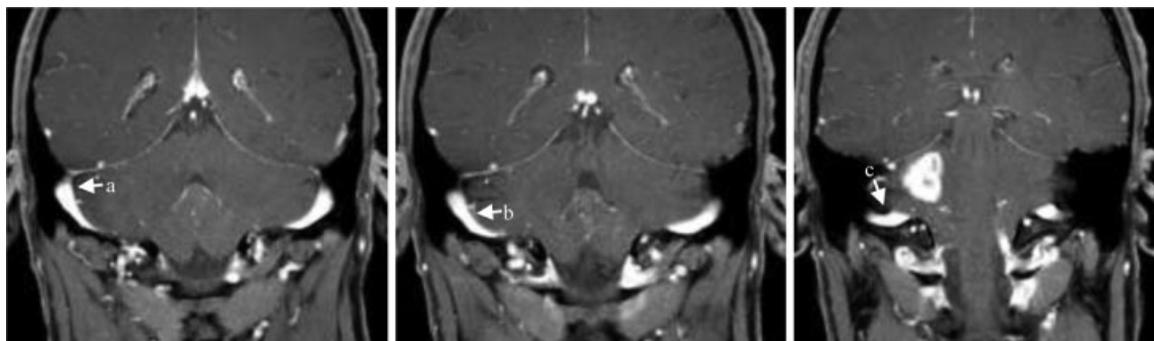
Measurements of the ipsilateral and contralateral proximal (a—at transition from transverse to sigmoid sinus), midpoint (b—midpoint of sigmoid sinus between proximal and distal measurements), and distal sigmoid sinus (c—at transition from sigmoid sinus to jugular bulb) were taken on preoperative and postoperative T1-contrast-enhanced coronal MRI. MRI, magnetic resonance imaging.
